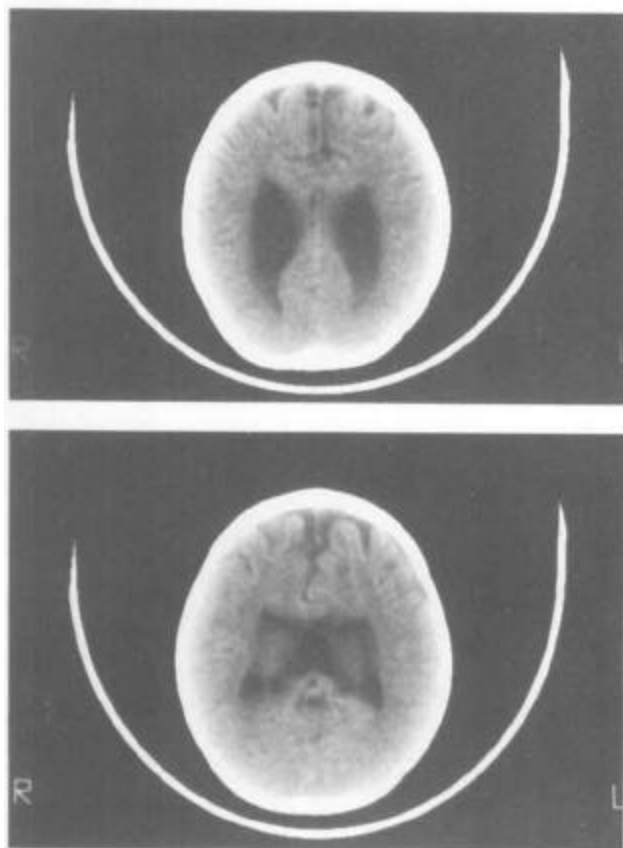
CT shows the brain anomaly including enlarged ventricles (*top*) and lobar holoprosencephaly (*bottom*).
